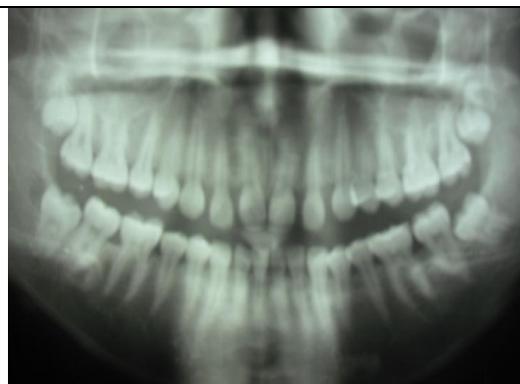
Orthopantomogram showing generalized horizontal bone loss in hereditary gingival enlargement.
